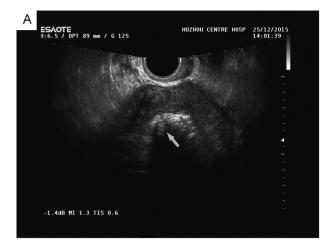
Ultrasonography inspection imaging. An ultrasound instrumentation was used to examine the pelvic organs. Figure A is the transvaginal ultrasonic image. The number of ultrasonic probe is EC1239-5. Figures B, C, and D are the abdominal ultrasonic images. The number of ultrasonic probe is CA6217-3.m The volume of the uterus is $10.9 \times 8.6 \times 10.8$ cm, The uterine cavity has accumulated fluid (green arrow). The hyperechogenic (blue arrow) with acoustic shadow (cyan arrow) are in the uterus. The ultrasonography was diagnosed as hysteromyoma.
